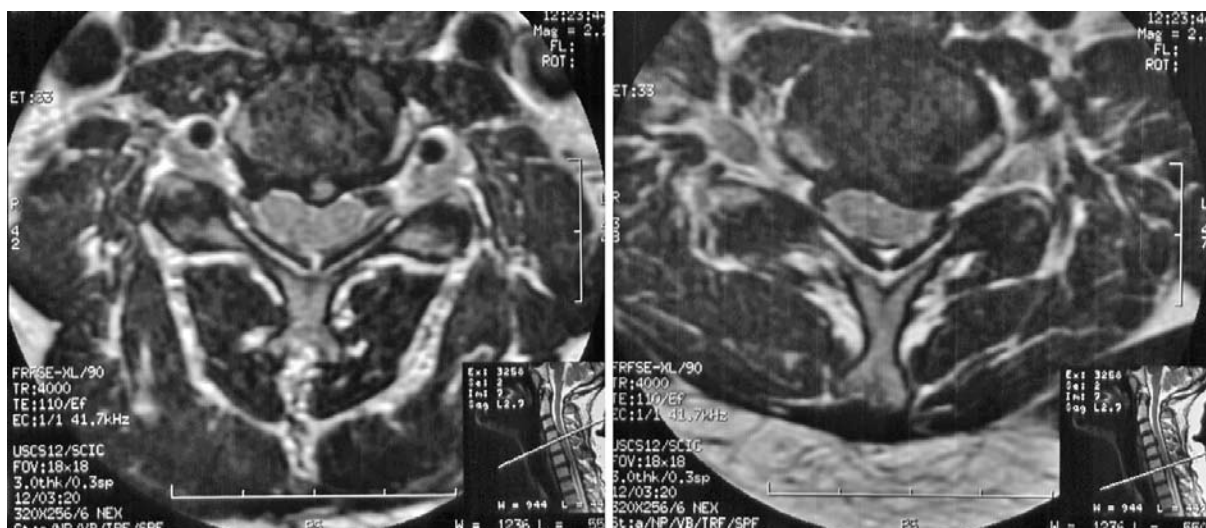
MR, T2-weighted images, axial plane. Disc herniations in two different patients. Left image: recent (active) herniation with bright appearance; right image: old (inactive) herniation with dark appearance
